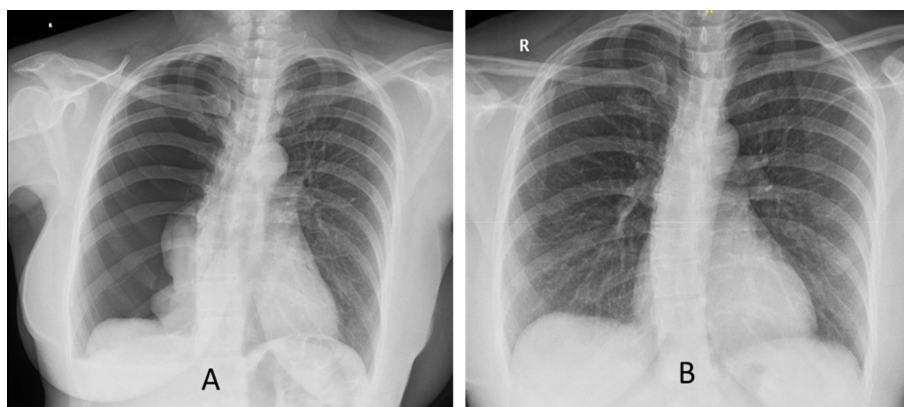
Right sided pneumothorax (4th recurrence) and 2B: X-Ray taken after medical thoracoscopy and talc pleurodesis.
